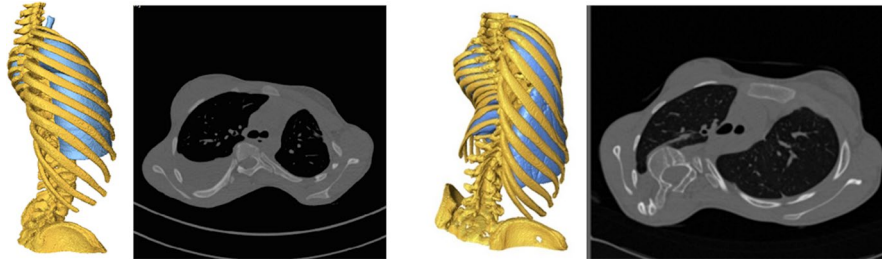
Example CT images with the 3D-reconstruction of two thoracolumbar AIS cases, which display an offset of the lung (blue) in the posterior region of the rib cage on the convex side of the spinal curvature
